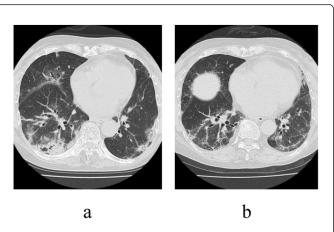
Chest CT on the initial visit (Figure 2a) showed GGO, reticular shadows, bullous formation, interlobular septal thickening and traction bronchiectasis at the pleural side of the bilateral lower lungs and around the bronchovascular bundles which improved after steroid pulse therapy. At the time of admission (Figure 2b), reticular shadows, curvilinear shadows and traction bronchiectasis were seen bilaterally predominantly in the periphery.
